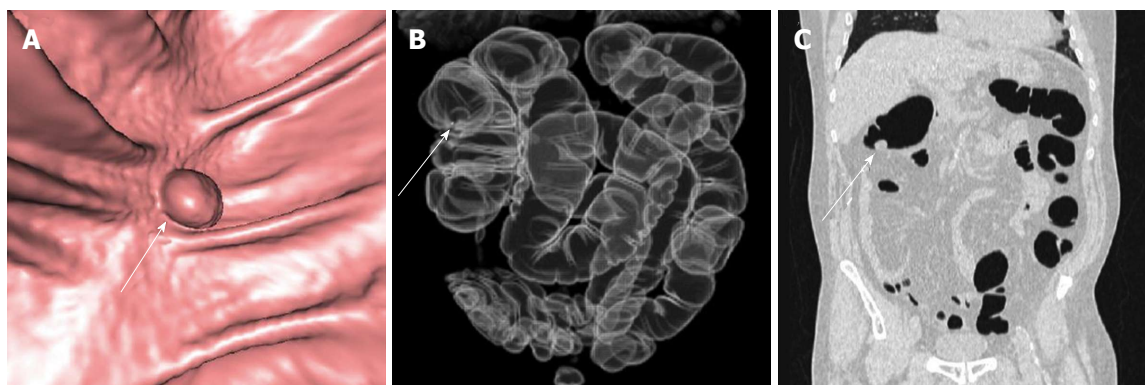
A 64-year-old male patient who underwent routine screening colonoscopy terminated due to severe discomfort. A: Virtual computed tomography (CT) colonoscopy detected a 1 cm polyp (arrow) in right colonic flexure, biopsy proved as adenocarcinoma; Fly-through with a 3D view of the polyp; B: The virtual X-ray reconstruction; C: Coronal reconstruction using the lung window shows the tumor clearly.
